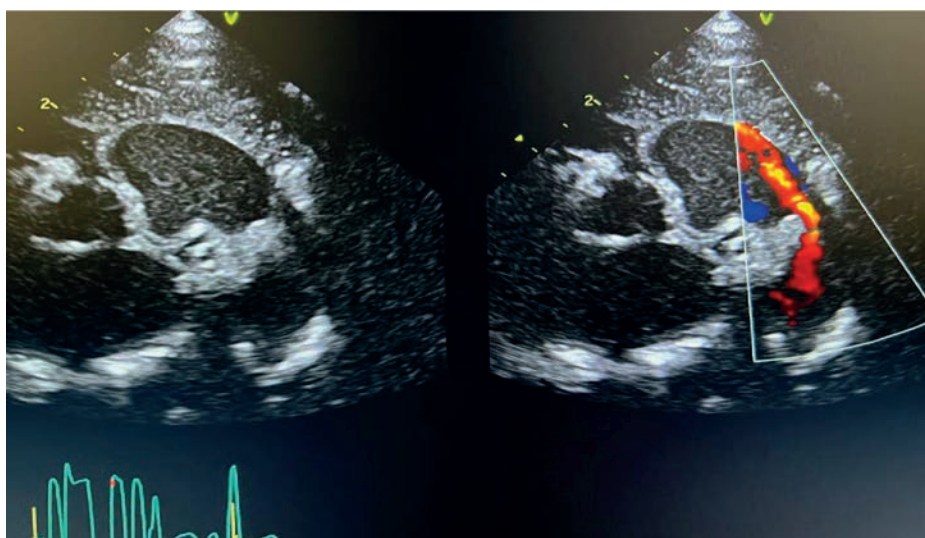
Patent ductus arteriosus bidirectional shunt-high parasternal view
